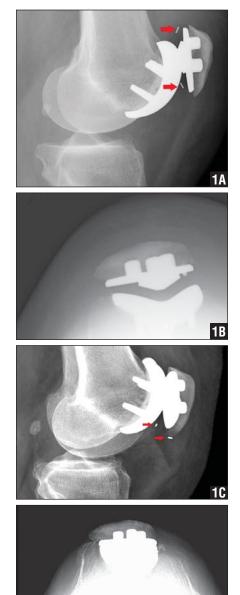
Lateral (A) and merchant (B) radiographs of the left knee showing the polyethylene in the trochlea and on the metal post (red arrows). Lateral (C) and merchant (D) radiographs of the left knee showing the polyethylene dislocated (red arrows). Anterior tenting of the patellar tendon by the dislocated polyethylene is demonstrated.
